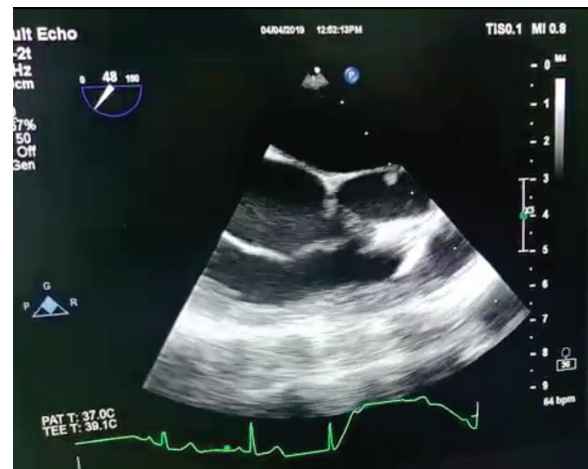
Transesophageal Echocardiography Showed Multiple Vegetation Attach of the Tip of Aortic Valves
